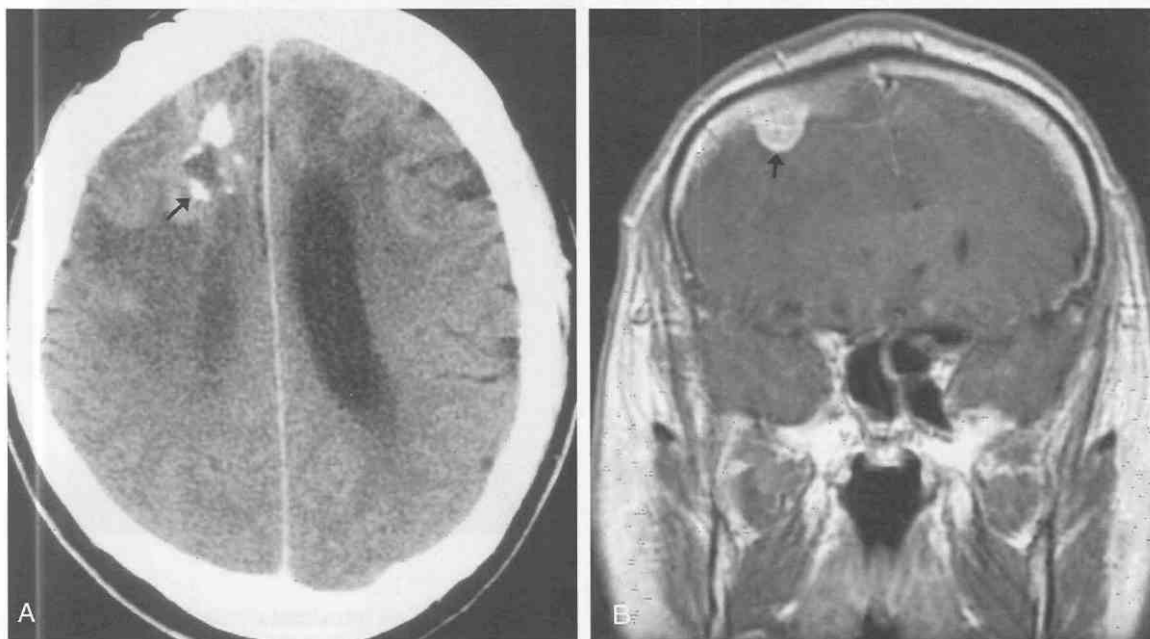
Gliosarcoma. *A*, Axial CT image following intravenous contrast demonstrates a lobulated mass with variegated contrast enhancement in the high right frontal convexity with multiple intratumoral calcifications (arrow) surrounding an area of central hypodensity that likely represents necrosis. The contrast enhancement crosses the midline into the high left frontal convexity. Extensive white matter hypodensity, likely representing edema, involves the surrounding frontal lobe white matter bilaterally. *B*, Coronal T1-weighted MR image post intravenous gadolinium confirms the presence of a lobulated high right frontal convexity contrast enhancing tumor and also clearly demonstrates the extensive spread of this tumor along the inner table of the skull bilaterally with bandlike meningeal thickening over the convexities of both cerebral hemispheres.
